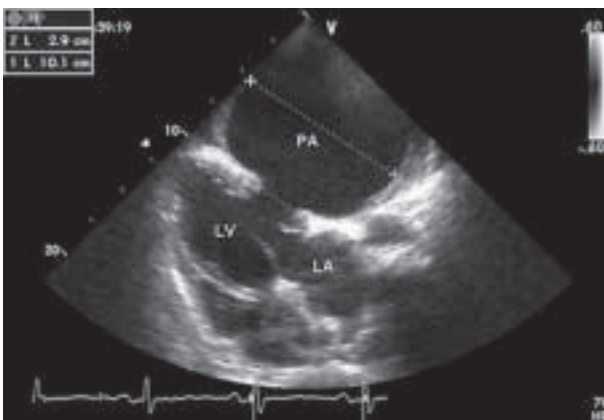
Transthoracic echocardiogram (substernal view) — pseudoaneurysm (PA) (diameter 10.1 cm) and orifice (diameter 2.9 cm); LV — left ventricle; LA — left atrium
